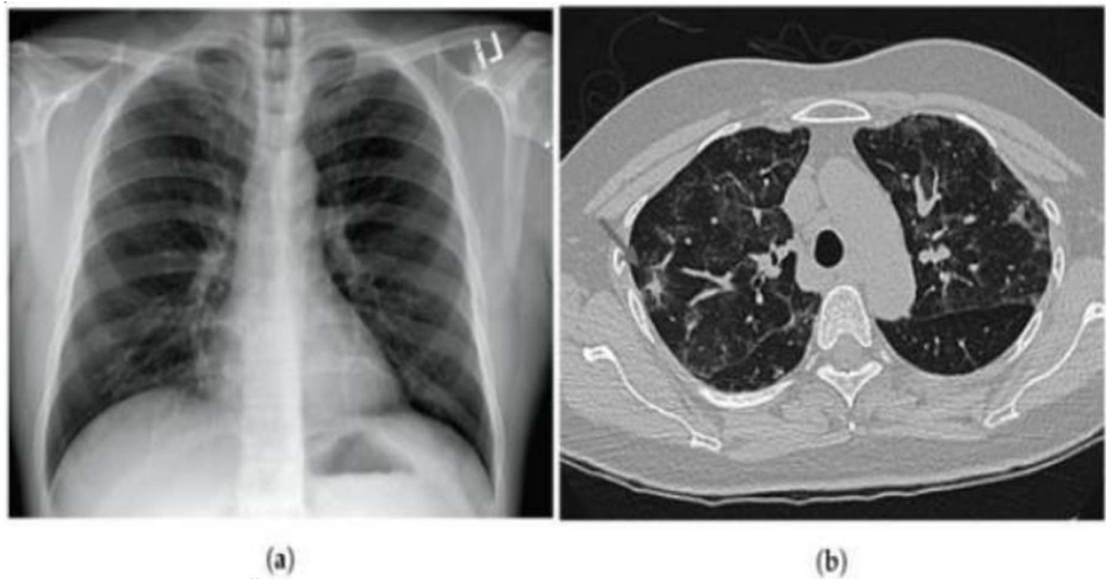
Thoracic medical imaging. (a) Example of CXR taken from [1]. (b) Example of a CT scan ^[27].
